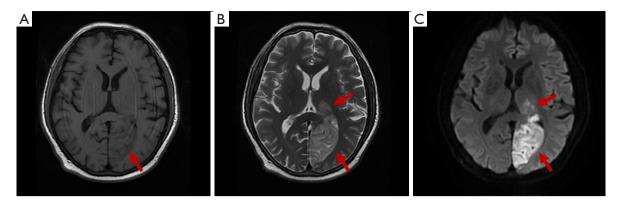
Cranial MRI. In the left occipital temporal lobe and thalamus, there are large patches of slightly longer T1 and slightly longer T2 signals (A), and T2 FLAIR (B) and DWI (C) are hyperintense (arrows). MRI, magnetic resonance imaging; FLAIR, fluid-attenuated inversion recovery; DWI, diffusion-weighted imaging.
